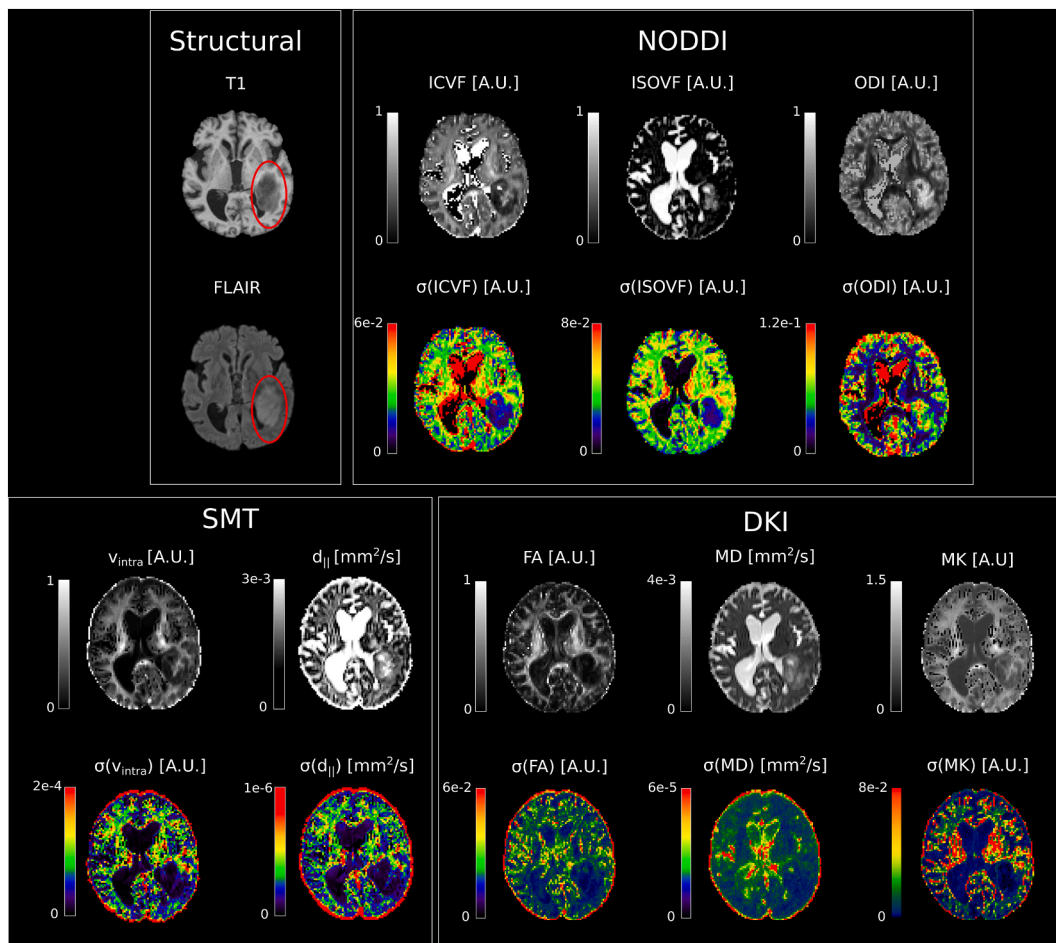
An example axial slice from a representative patient showing its T1w and FLAIR structural images as well as both NODDI/SMT/DKI metrics (first row of each box, grey scale) along with their standard deviation map (second row, jet scale).
